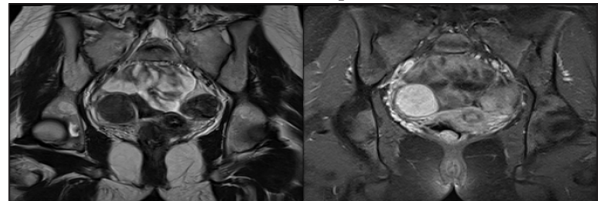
T2 coronal MRI sequence & Fig 5b T1 post contrast MRI sequence showing lesion in coronal plane in right adnexa. Right ovary not separately visualized.
